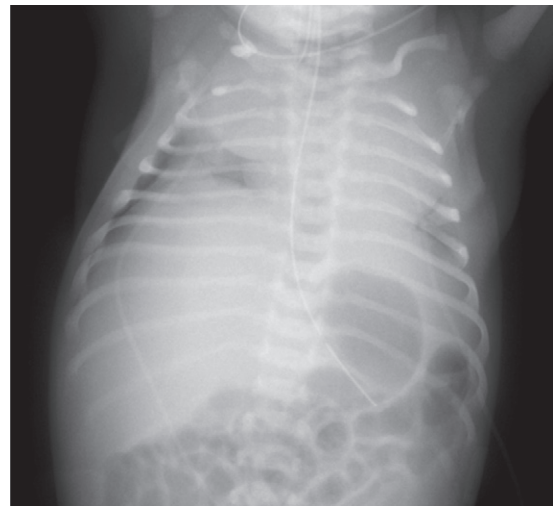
Diffusely thin ribs without fractures in a neonate with Potter sequence. Frontal chest radiograph shows diffusely thin ribs with poorly expanded hypoplastic lungs, complicated by right lateral pneumothorax. Abdominal US findings (not shown) revealed bilateral enlarged echogenic kidneys consistent with autosomal recessive polycystic kidney disease.
